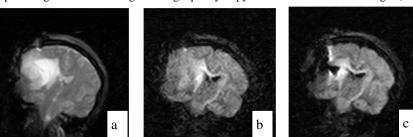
Intraoperative MRI of a patient with a right temporal huge tumor. (a) T2-weighted image, (b) DW image before removal, and (c) DW image after removal.
